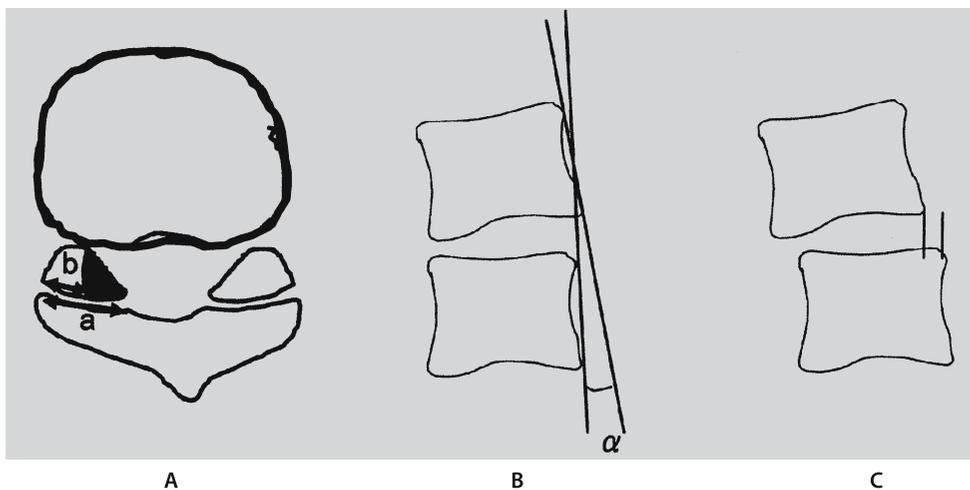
Radiographic measurements for the thoracic spine. A The residual ratio of the lateral part of a facet joint on CT scans was determined as $b/a \times 100$ (%). B Degree of thoracic
